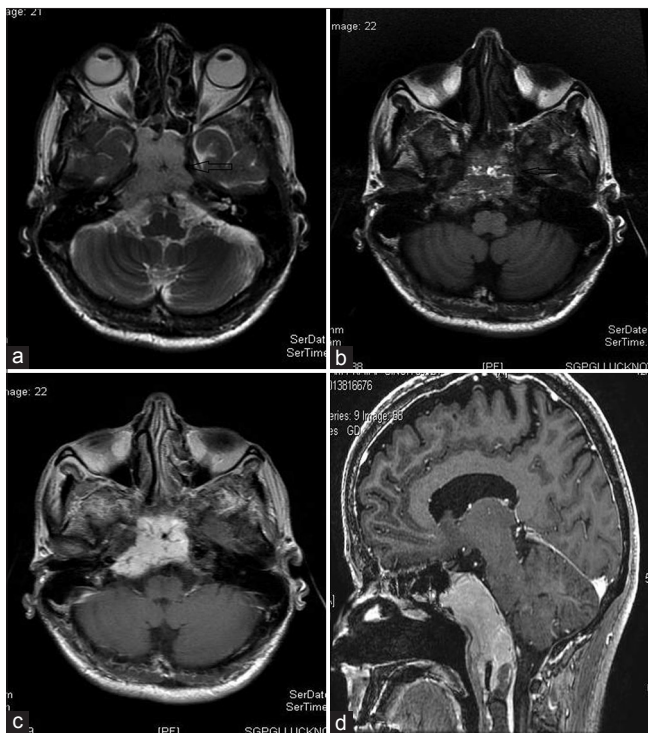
(a) Axial T2-weighted image at the level of skull base showing hyperintense expansile clival lesion with small hypointense foci. (b) Same lesion appears isointense on axial T1-weighted image and shows focal hyperintensities suggestive of hemorrhage. (c) Lesion showing intense contrast enhancement. (d) Sagittal image shows enhancing clival lesion (arrows)
